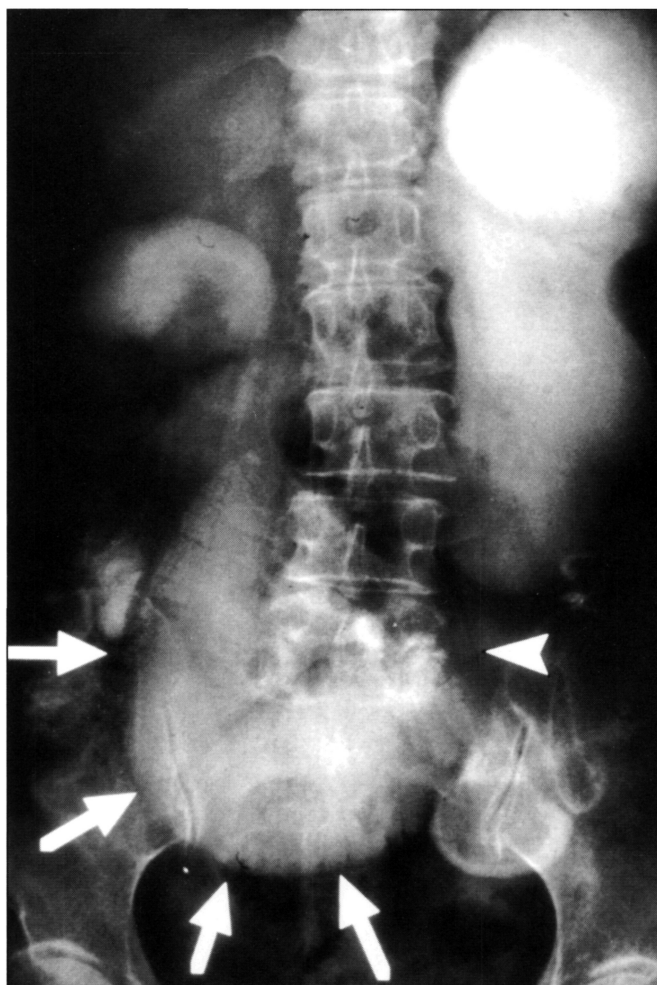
Abdominal X-ray after ingestion of contrast medium. A dilated loop of the small bowel is indicated by arrows. The anastomotic site is identified by the staples, as indicated by the arrowhead.
